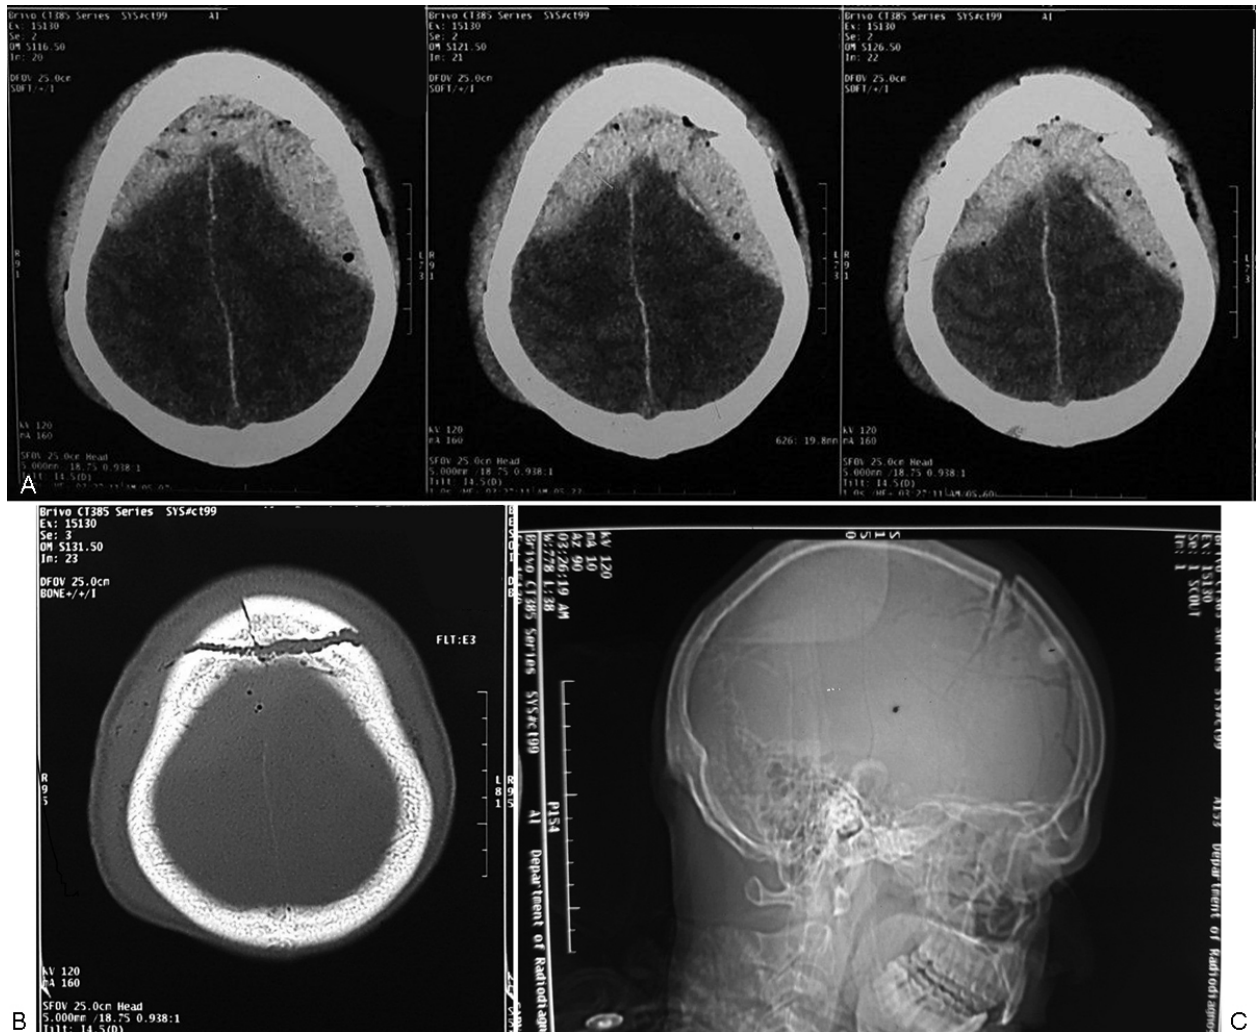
CT brain axial sections (A) showing a large vertex extradural hematoma extending bilaterally. The axial (B) and sagittal (C) bony cuts clearly show coronal suture diastasis (case 1).
